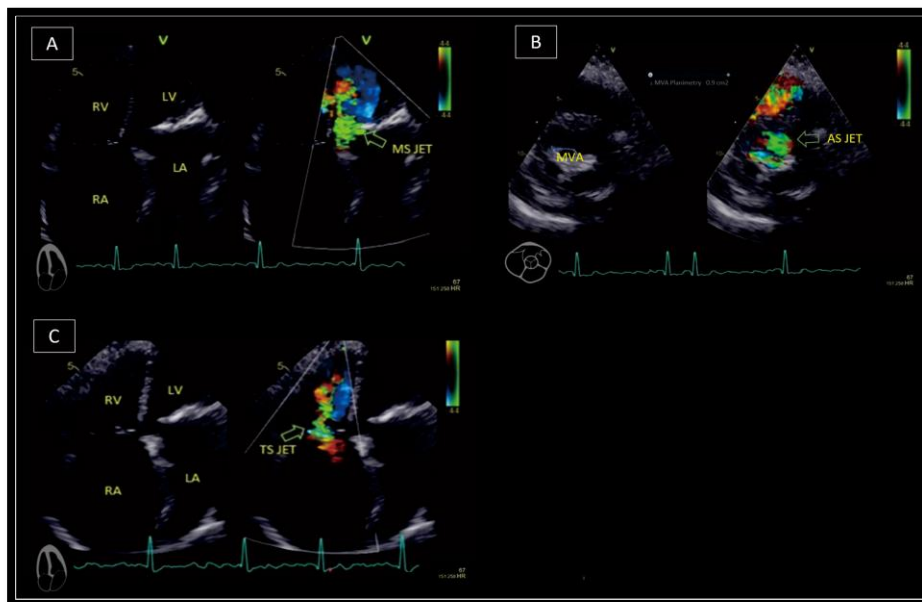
Transthoracic echocardiography showed (A) mitral stenosis in 4 chamber view, (B) The mitral valve area planimetry was 0.9cm² from parasternal short axis
